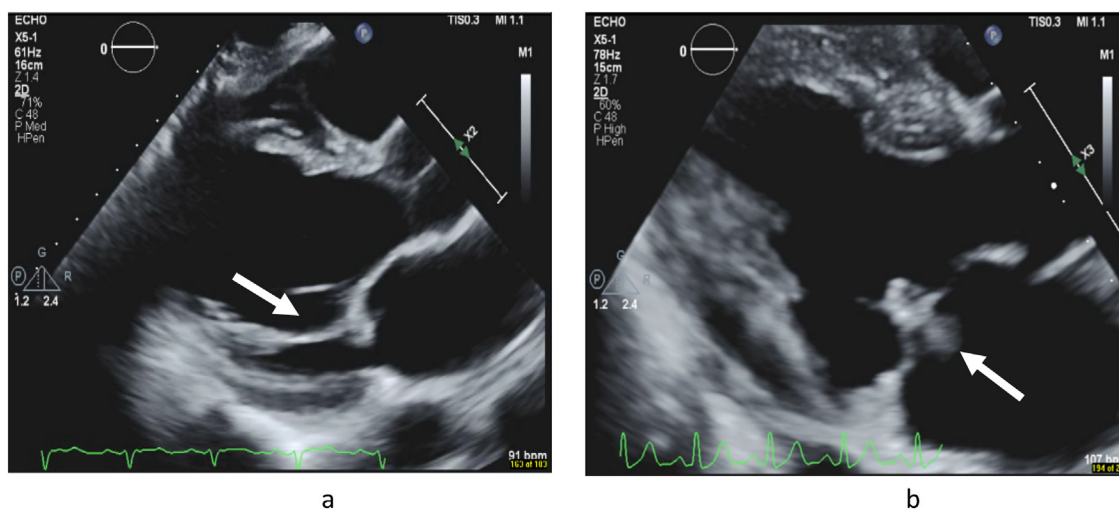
a) TTE parasternal long axis view on Day 5 demonstrating thickened TTE mitral valve leaflets. b) TTE parasternal long axis view on Day 10 demonstrating a vegetation on the mitral valve.
